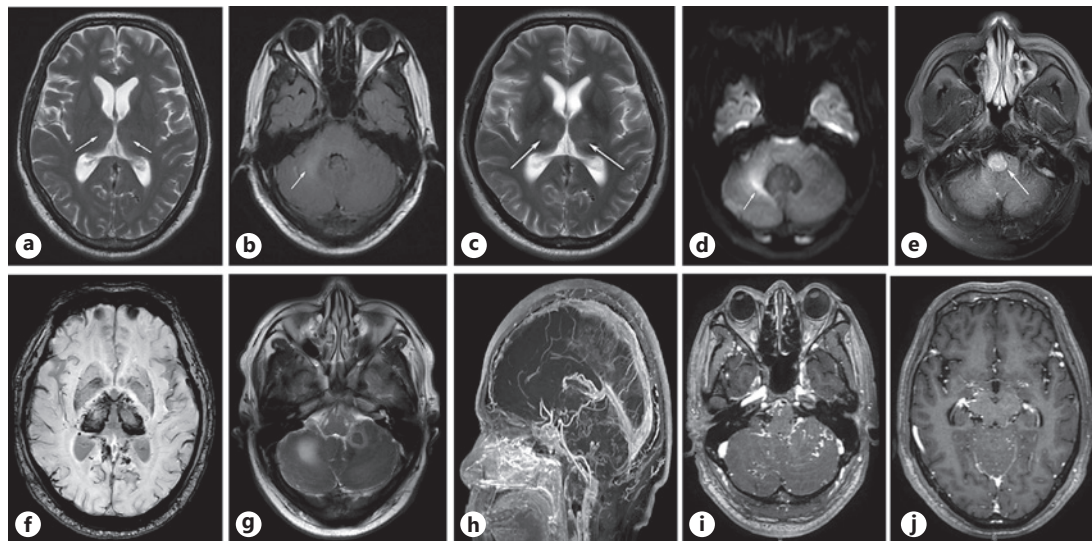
Brain MRI after 12 days from baseline. a, b The left thalamus and right cerebellar bridge arm show T2WI and T2 FLAIR slightly high signal and no enhancement, and the scope of the lesion is significantly reduced compared with the previous; brain MRI after 50 days from baseline. c, d Bilateral thalamus and right cerebellar pontine arm are enlarged compared with the previous range; e T2 FLAIR new brainstem high signal intensity; brain MRI after 60 days from baseline. f Bilateral thalamus and medial temporal lobe SWI show significant patchy enhancement and multiple dotted strip SWI with the significant low signal; g the left pontine arm node shows T2WI low signal with surrounding ring of slightly high signal, and the right cerebellar pontine arm shows patchy T2WI slightly high signal; h left transverse sinus, ethmoid sinus, superior sagittal sinus filling defect; i, j many tortuous stripes in the cerebellum and bilateral basal ganglia area.
